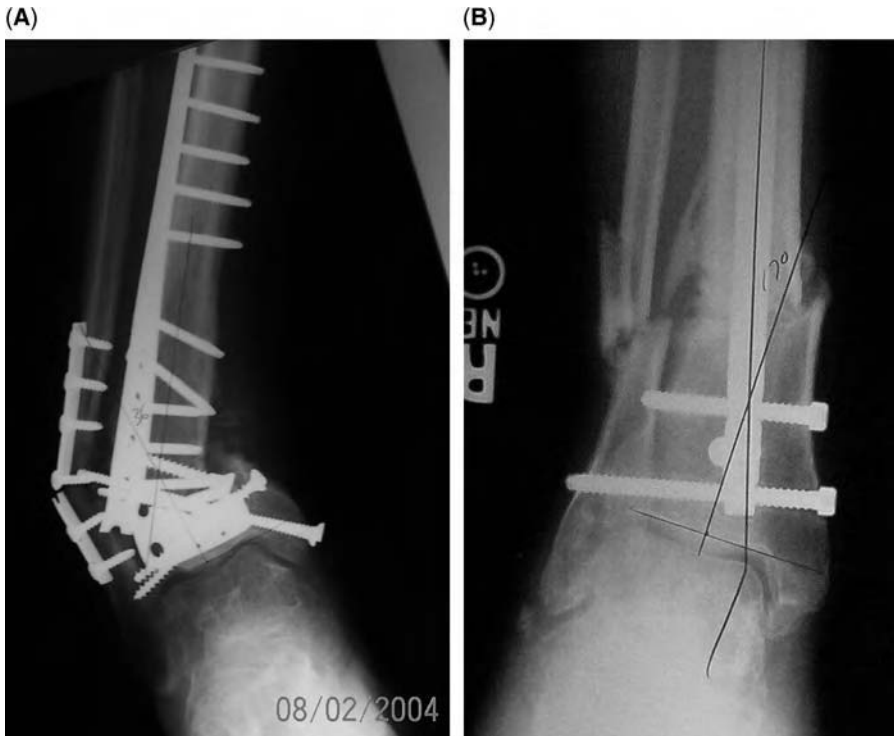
(A) Anteroposterior (AP) X-ray of an atrophic mobile nonunion of the distal tibia/fibula with deformity and retained hardware. (B) AP X-ray showing a normotrophic partially mobile nonunion with retained intramedullary nail and valgus deformity.
